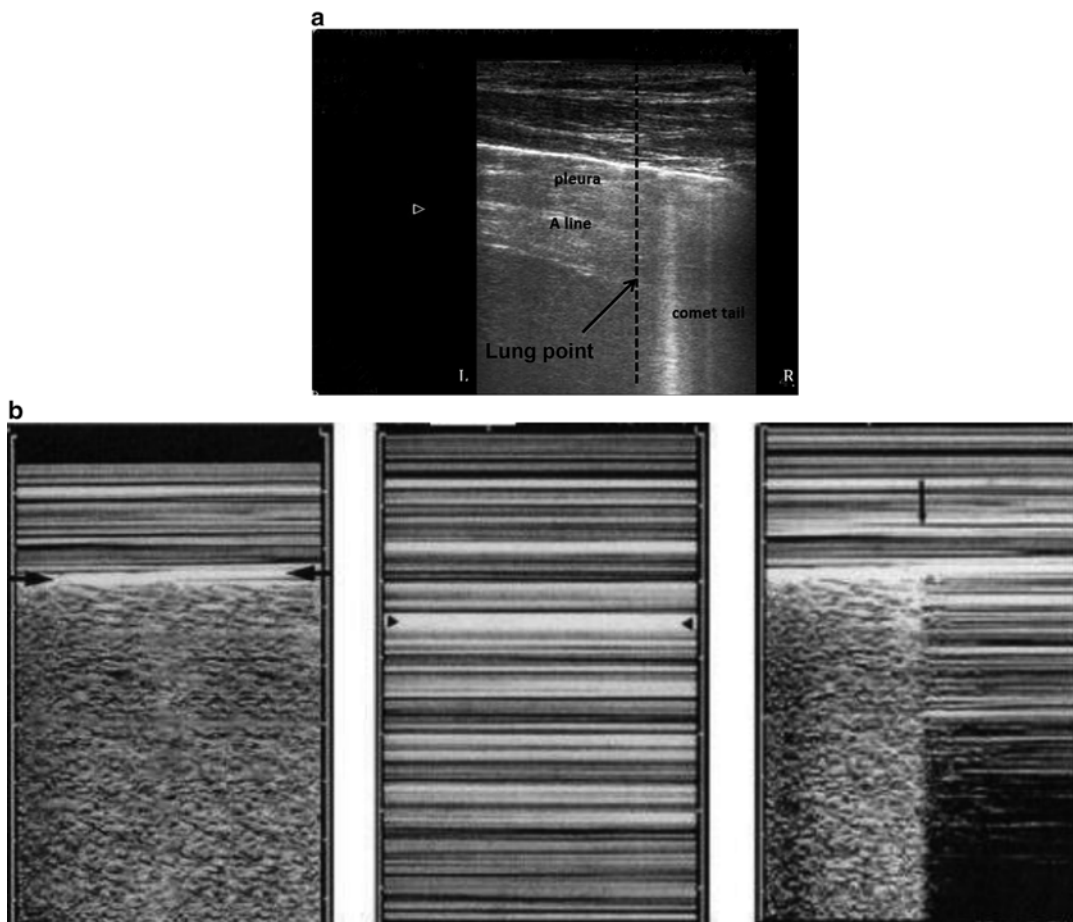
Thoracic ultrasound. (a) A 10 MHz probe is used to image the pleural surface in a patient with shortness of breath after blunt chest trauma. The bright horizontal line represents the pleura. The horizontal reverberations are referred to as “A” lines, which are a sign of pneumothorax. Similarly, absence of rib shadowing, also called “comet-tail artifact,” is typical of pneumothorax. This image thus depicts the lung point: on the left
